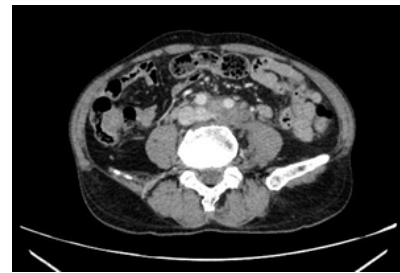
Pre-treatment abdominal CT scan show that there was multiple peritoneal lymph nodes along the abdominal aorta and bilateral iliac artery
